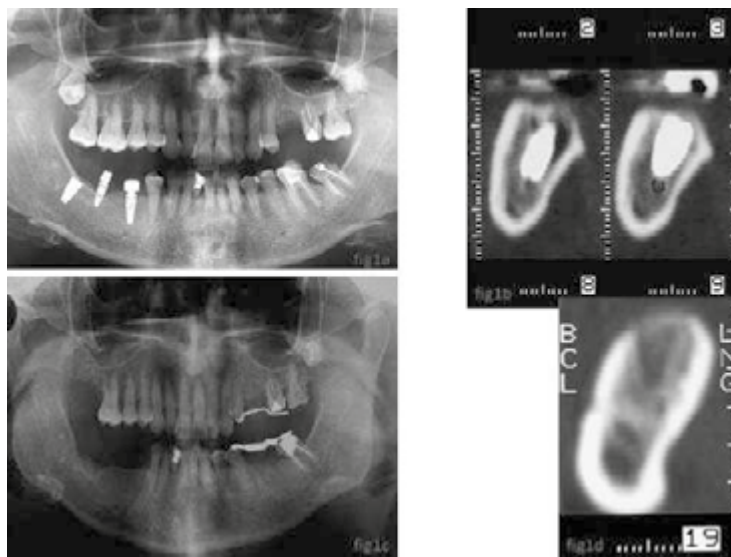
A) Baseline orthopantomograph exam. B) Multiple CT axial views showed that the implants were placed in contact with the alveolar inferior nerve. C) Orthopantomograph 30 days following the removal of the failed implants. D) CT Axial view of an healed area in the site of a previously failed implant
